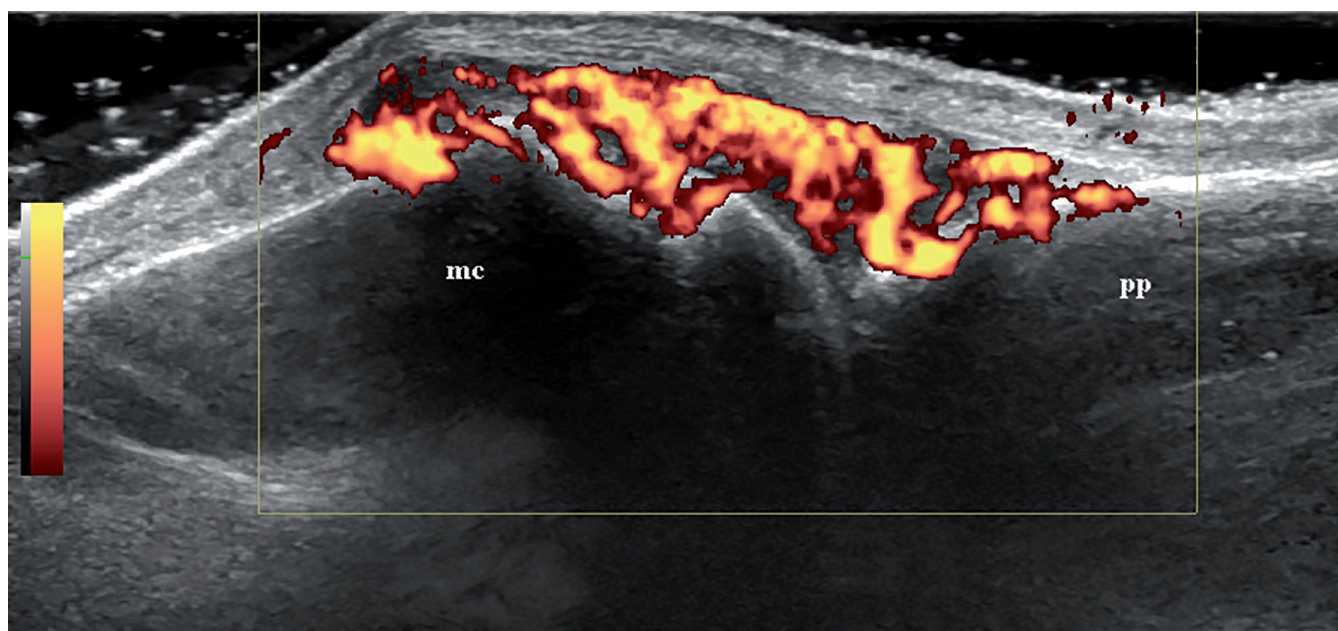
Longitudinal ultrasound image of the dorsal aspect of a metacarpophalangeal joint that shows grey-scale synovial hypertrophy with high power Doppler signal in a patient with rheumatoid arthritis. mc: metacarpal bone; pp: proximal phalanx.
